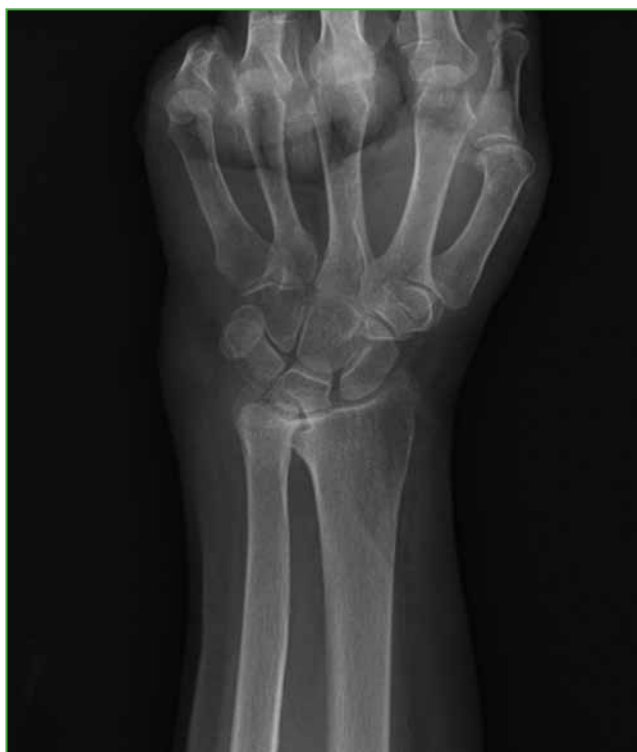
Wrist radiograph, AP view, showing distal radioulnar osteoarthritis.
